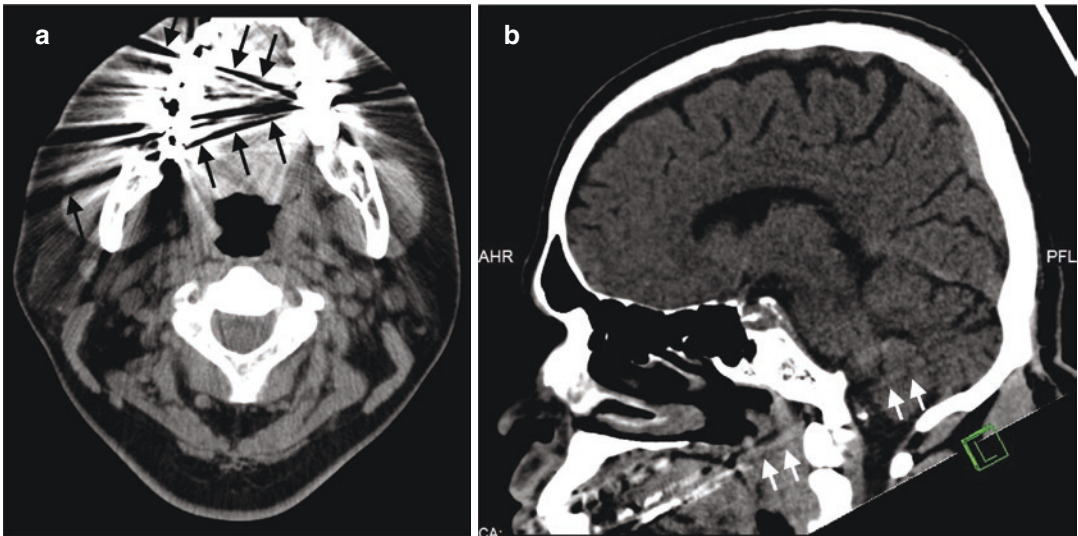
Streak artifacts in two different patients. (a) Axial CT image shows prominent streak artifacts (black arrows) from dental amalgam, which limits assessment of the adjacent structures in the mandible. (b) Sagittal CT
